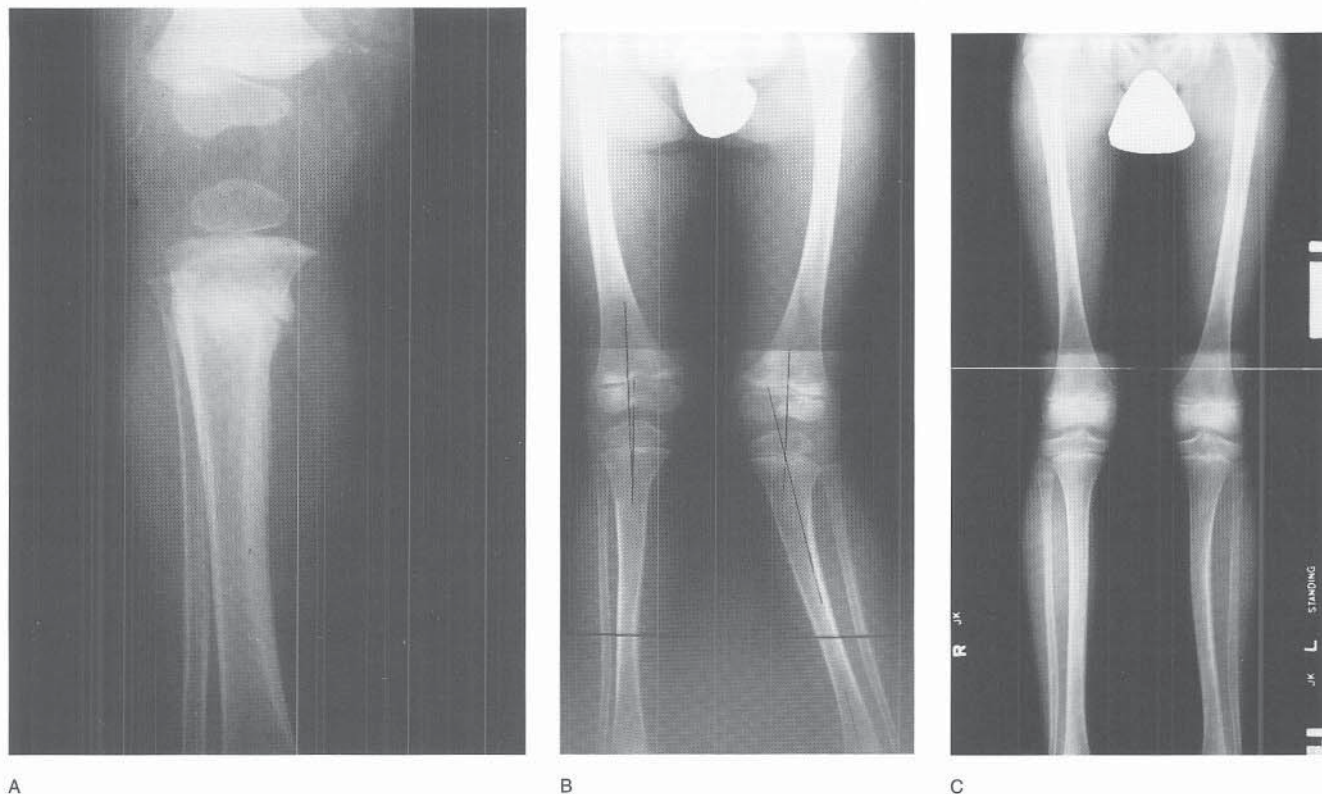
A, Nondisplaced fracture of the left proximal tibia in a 16-month-old boy. B, Radiographic appearance at age 4 years 9 months. The left lower extremity had a 17-degree valgus deformity, which was progressive (and expected) since cast removal 3 years earlier. C, Radiographic appearance at age 11. The valgus deformity had completely resolved clinically. A mild zig-zag deformity was seen radiographically. No treatment was prescribed.
